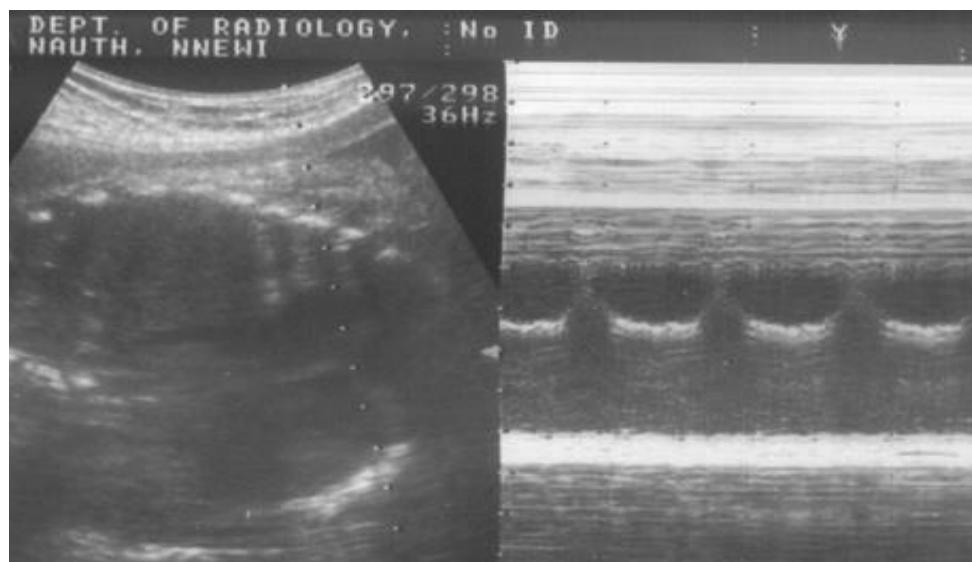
Sonogram showing the foetal heart activity and heart beat tracing in M-mode echocardiography.
